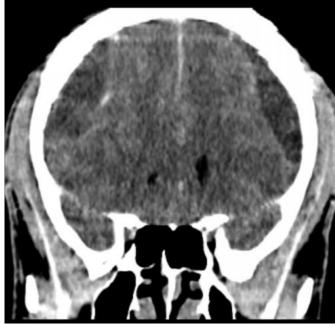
Brain CT scan showing bilateral chronic subdural haematoma in axial (A) and coronal (B) views.
